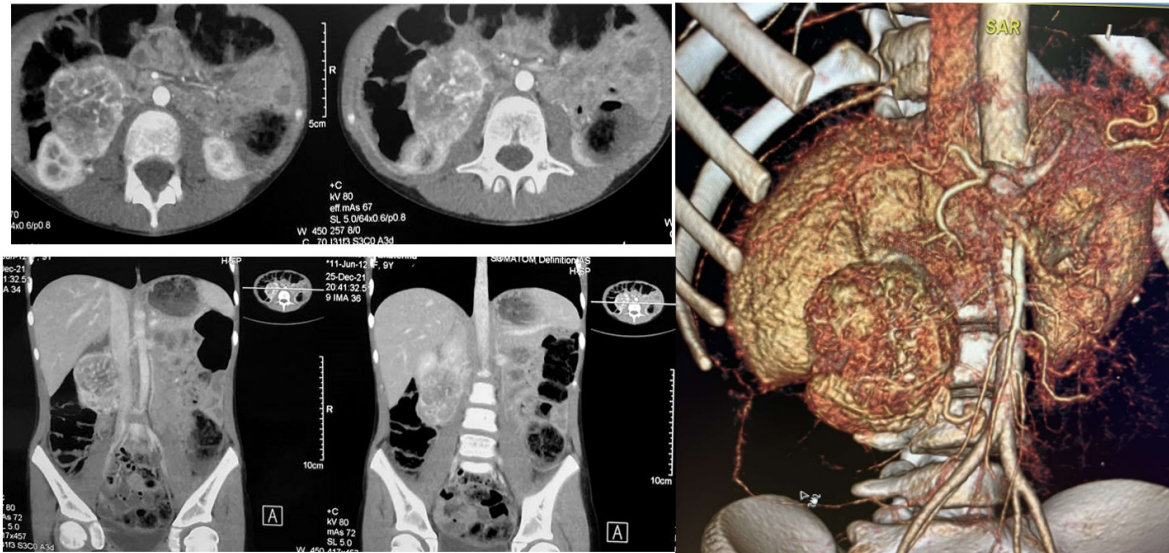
Patient, 9 years old. CT with intravenous contrast with iogexol performed preoperatively. Explanations in the text.
